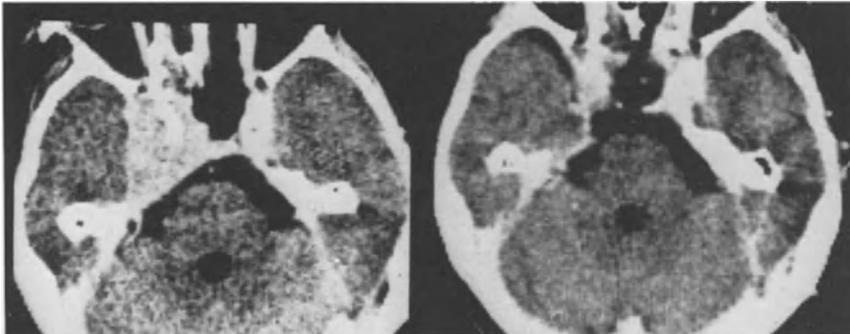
Postoperative CCT scan of a giant invasive pituitary adenoma with parasellar extension into the left CS and middle cranial fossa as well as supra- and intrasellar tumor growth, which was treated first by the combined transthemoidal-transsphenoidal approach to deal with CSF leakage, and then by the left pterional medial approach with total removal of the tumor, as demonstrated by the postoperative CT scan
